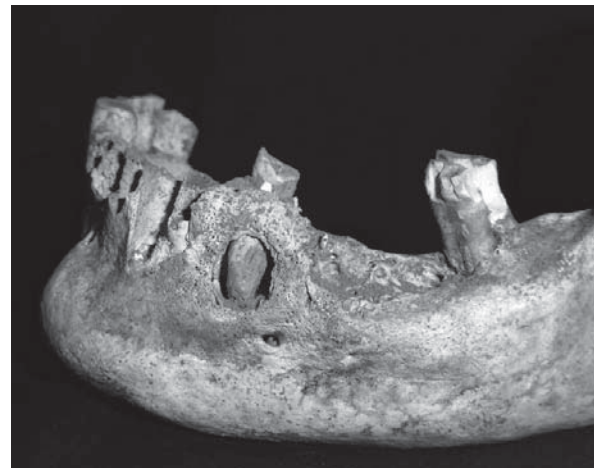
Periapical lesion on left mandible of F008 SK01 (photo: Tina Jakob)
